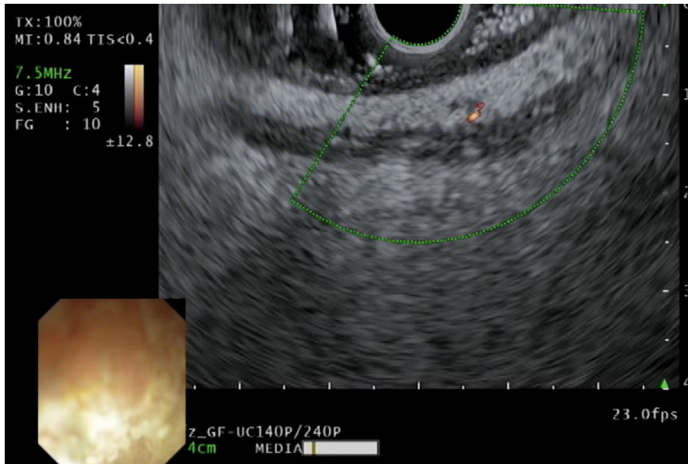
Endosonographic appearance of transmurular thickening of rectal wall in active ulcerative colitis.
